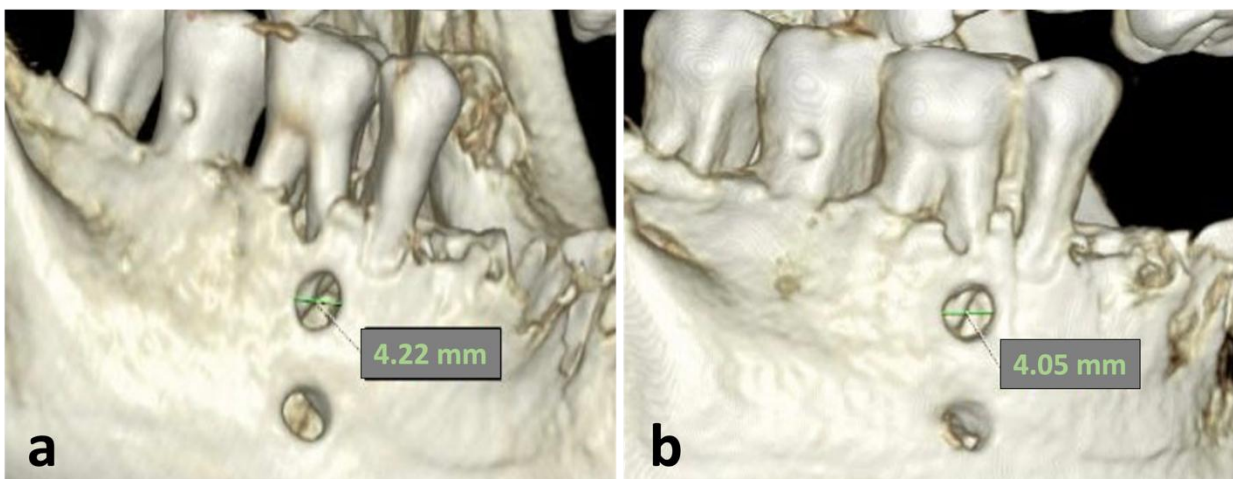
Measurements of the created fenestration defect (a). High-resolution CBCT (b). Standard resolution CBCT on 3D volume rendering.
